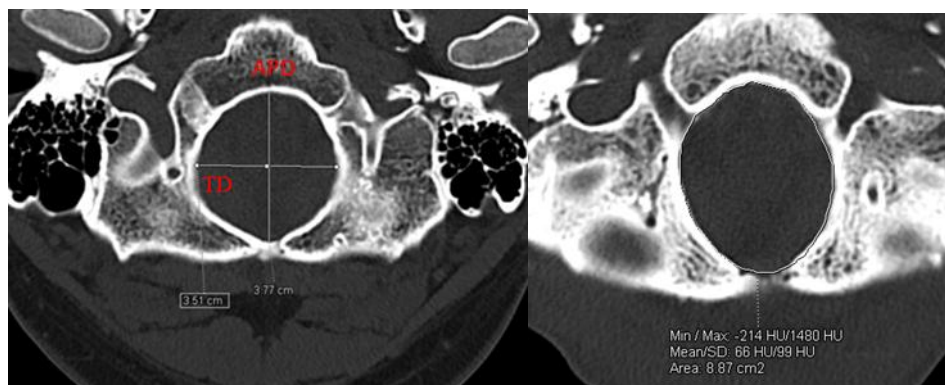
Measurement of foramen magnum parameters on computed tomographic images. (A) Antero-posterior diameter (APD) and transverse diameter (TD). (B) Area.
